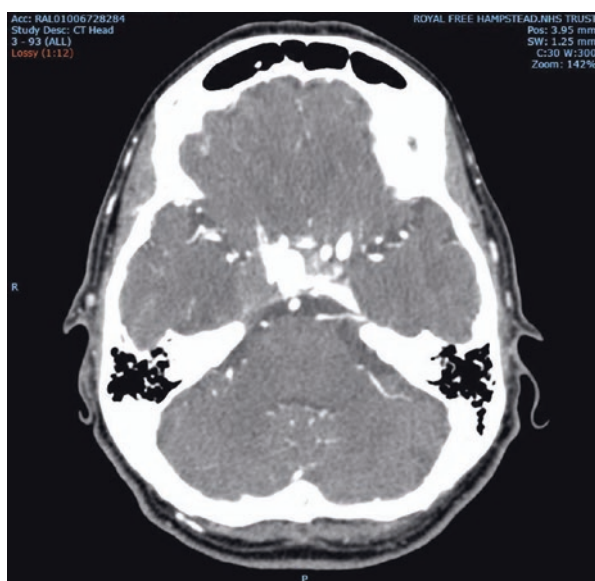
CT of orbits: there is expansion of the right cavernous sinus with moderately hyperdense material, with a degree of the medial extension towards the sella turcica. There is accompanying erosion of the right anterior and posterior clinoid processes, and attenuation of the superior aspect of the petroclival junction. This demonstrates a partially thrombosed large intracavernous aneurysm, measuring 20 mm in maximum dimension in the sagittal plane
